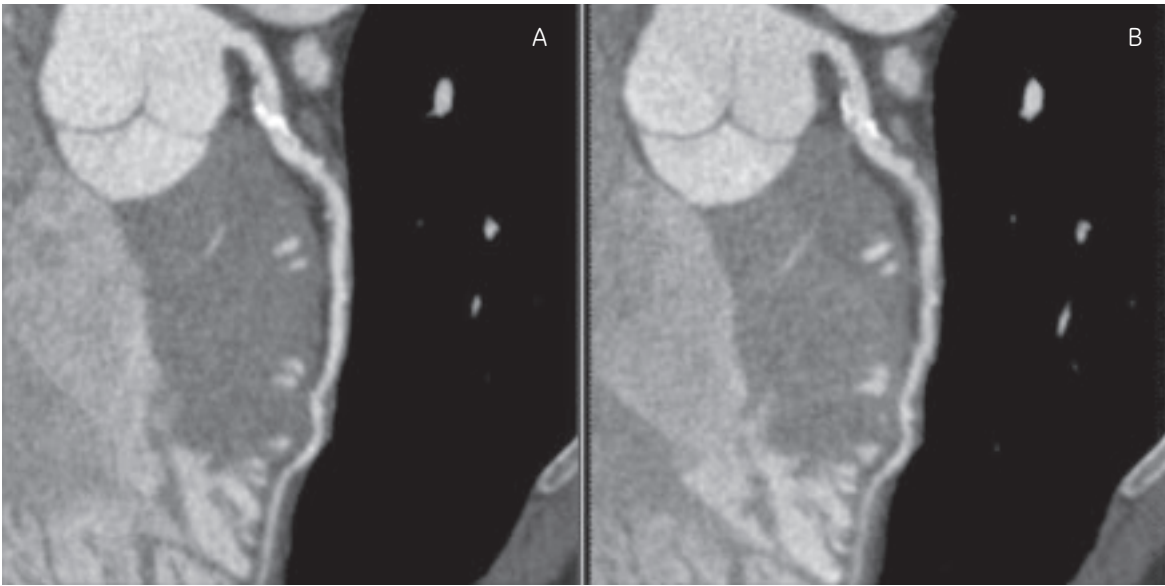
The CT scanner will set the radiation padding length on either side of the 75% window based on the heart rate. I routinely override this function and use a 10 msec pad.
